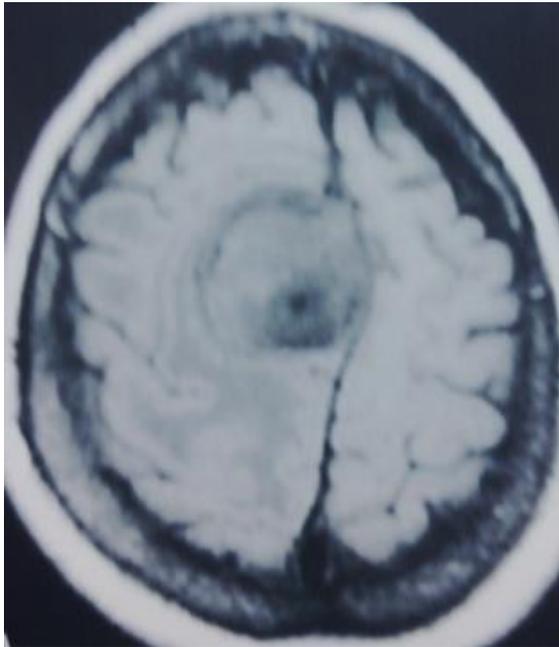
MRI Scan shows axial T1weighted shows a right parasagittal isointense mass. The focal low intensity is consistent with calcification.
